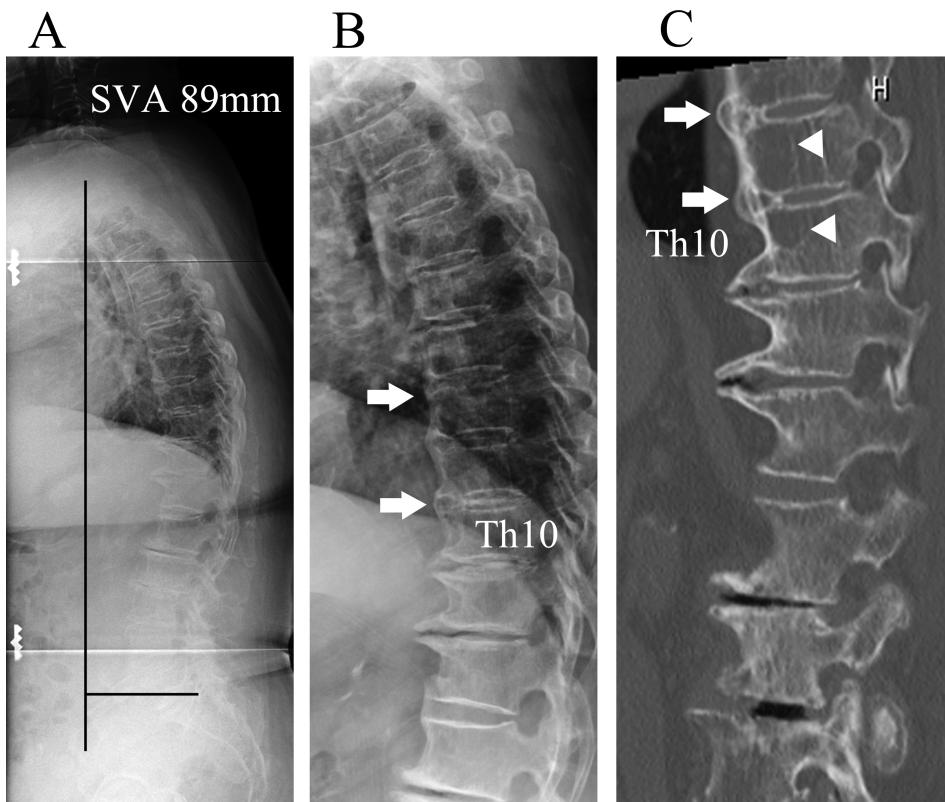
A, Preoperative standing sagittal radiograph demonstrating decreased lumbar lordosis and C7 plumb line shifted to the anterior by approximately 9 cm (lumbar lordosis = 30°, pelvic tilt = 31°, sagittal vertical axis = 89 mm, pelvic incidence-lumbar lordosis = 27°). B, Preoperative lateral radiograph of the thoracic spine revealing abnormal confluent hyperostosis in anterior longitudinal ligaments from Th5 to Th10 (arrows). C, Preoperative sagittal reconstructed computed tomographic scan demonstrating abnormal confluent hyperostosis in the anterior longitudinal ligaments (arrows) and local reduction of trabeculae in the anterior vertebral body (arrowheads) above Th10. SVA indicates sagittal vertical axis.
